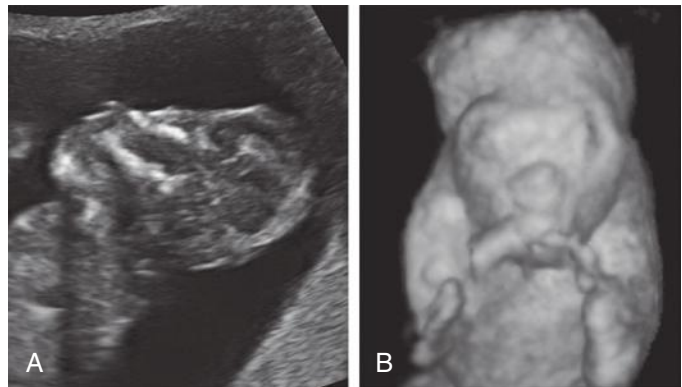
Anencephaly at 13 weeks' gestation. A, Two-dimensional midline sagittal sonographic image; B, three-dimensional sonogram.
